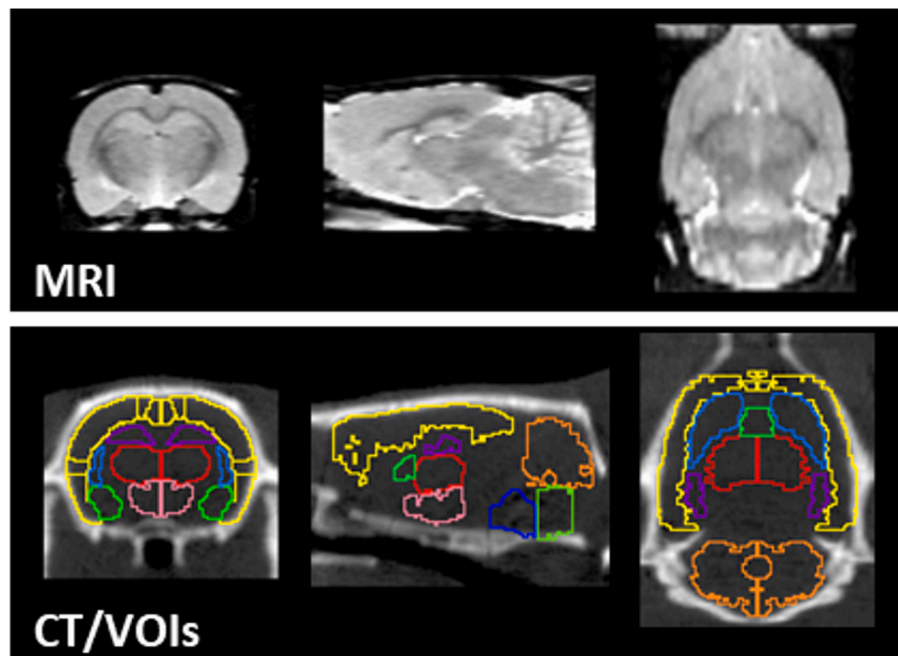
The upper row shows the coronal, sagittal and transaxial views corresponding to the MRI brain template used for PET and CT images co-registration. The bottom row shows a sample CT image with the volumes of interest (VOIs) of the brain areas used for quantification of the regional metabolic activity by [18F] FDG PET.
